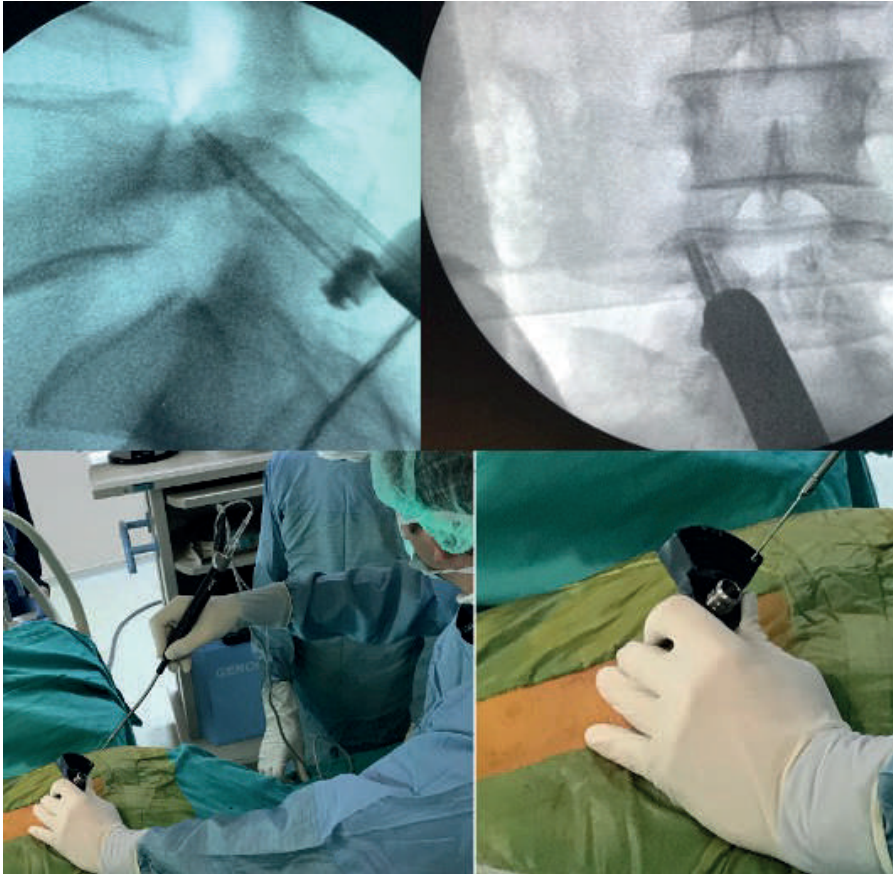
Pars preparation using an ultrasonic bone scalpel under fluoroscopic guidance. Intraoperative fluoroscopic images and operative photographs demonstrating preparation of the pars interarticularis using an ultrasonic bone scalpel. Under fluoroscopic guidance, the pars region is carefully contoured and the defect margins are refreshed to facilitate subsequent fixation and promote bone healing during pars repair surgery.
